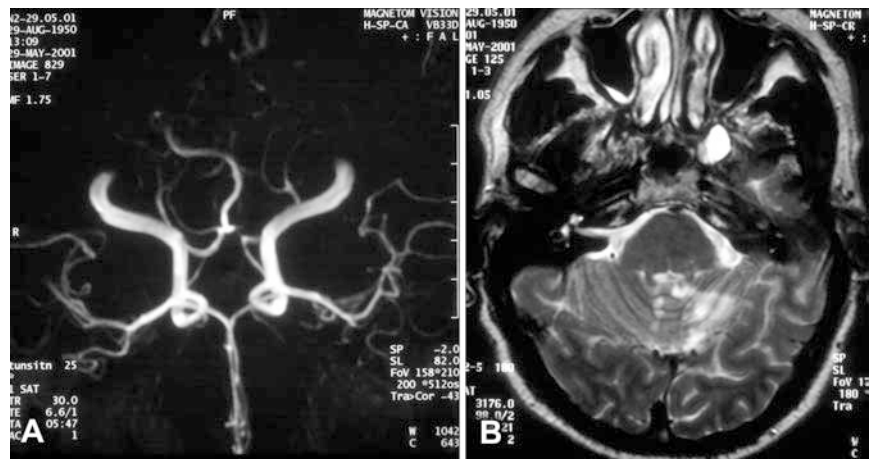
Patient 1: Radiological follow-up. Time-of-flight magnetic resonance (MR) angiography (TOF-MRA) performed on the following day demonstrates normal flow in the dominating vertebral artery (VA) and the basilar artery (BA) (A). T2-weighted MRI (B) shows a subtle increase of the infarction volume in the territory of the superior cerebellar artery (SCA)
